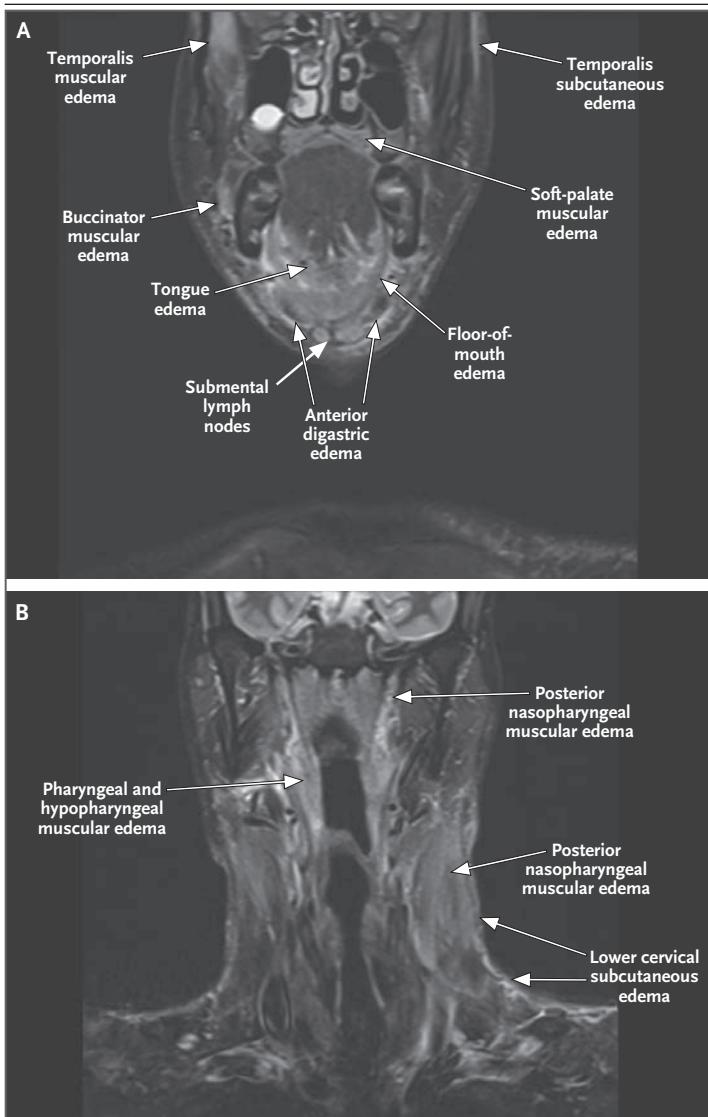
MRI of the Head and Neck.
